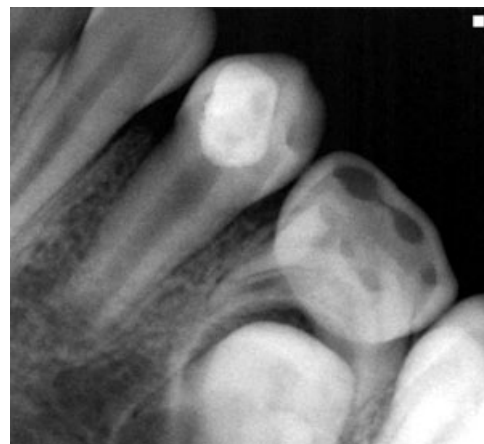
Immediate postoperative periapical radiograph showing pulp capping with MTA, cotton and temporary filling material.
